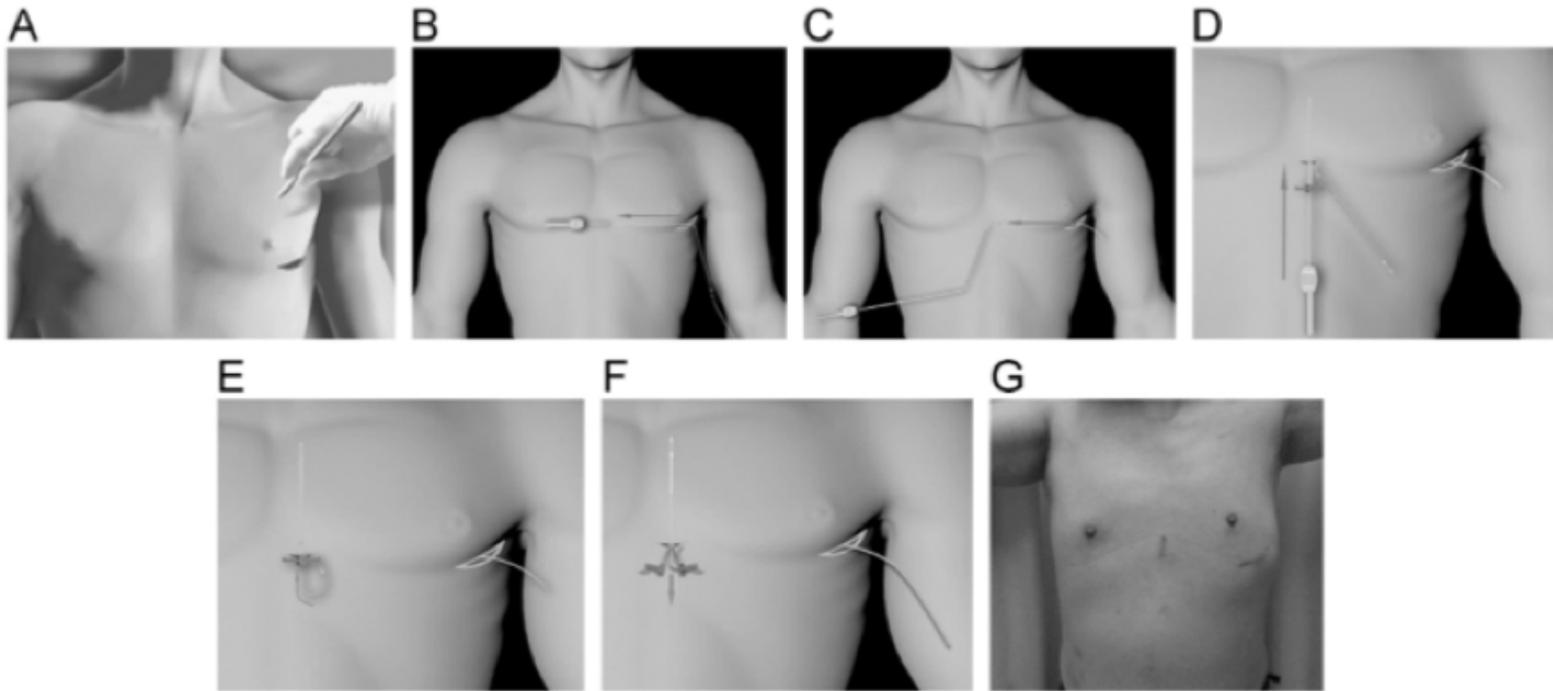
A: Creating the device pocket. B: Connecting distal end of electrode to the electrode insertion tool (EIT). C: Pulling the lead to the inferior parasternal incision. D: Tunneling the EIT and peel-away sheath to the superior parasternal position without making a parasternal incision. E: After the EIT is removed, the electrode is inserted in the sheath. F: Peeling away the sheath, leaving the electrode in the desired subcutaneous position. G: Final result after 2 weeks of follow-up.
